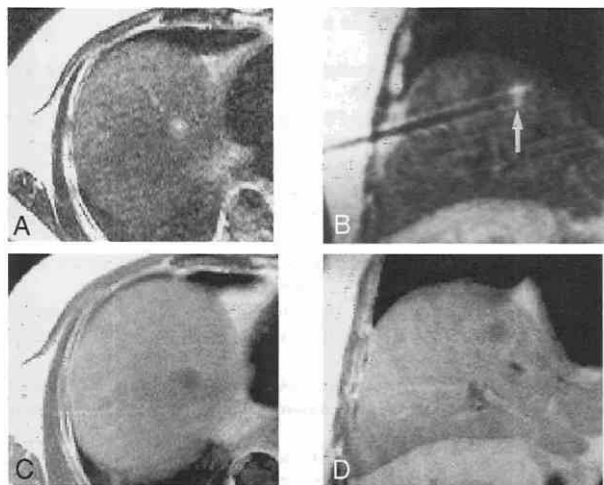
A, Turbo spin-echo T2-weighted axial image demonstrates a 1-cm metastasis near the dome of the liver. B, Turbo spin-echo T2-weighted coronal image demonstrates the radiofrequency electrode, placed under MRI guidance, with its tip centered within the tumor nodule. Axial (C) and coronal (D) contrast-enhanced T1-weighted images at the end of the ablation session demonstrate a hypointense zone corresponding to the treated metastasis. The lesion was treated to ensure complete ablation of the tumor plus a thin surrounding margin of normal tissue.
